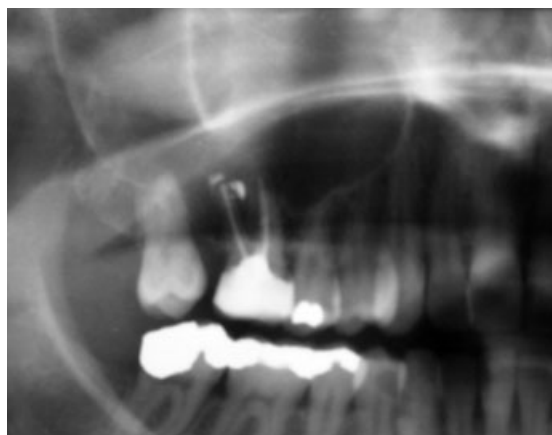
Detail of a panoramic X-ray (performed alio loco) after root canal treatment showing extrusion of the root filling material beyond the apex at the disto-buccal root of the right upper first molar.
